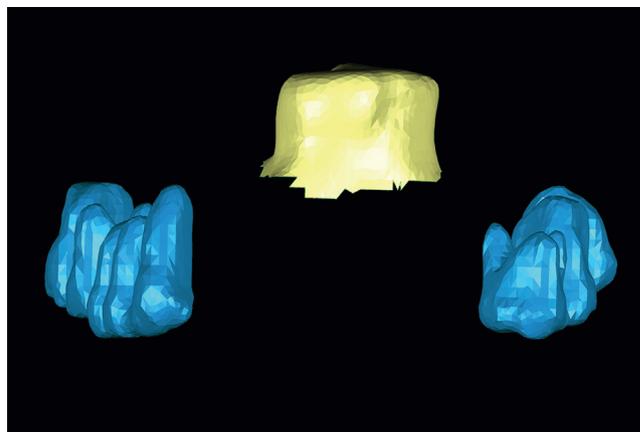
Relative positions of "CT image of dentition" and "CT image of soft tissue." CT, computed tomography.
